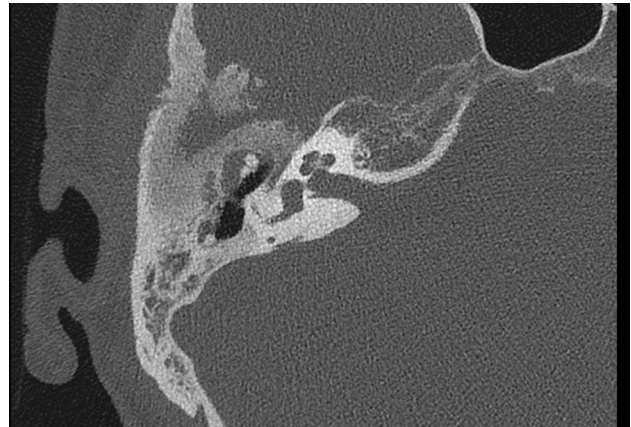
Temporal bone computed tomography, axial unenhanced scan. Trabecular remodeling of a pyramid extending into squama of the temporal bone is present. A typical calcification of the soft-tissue mass is evident
